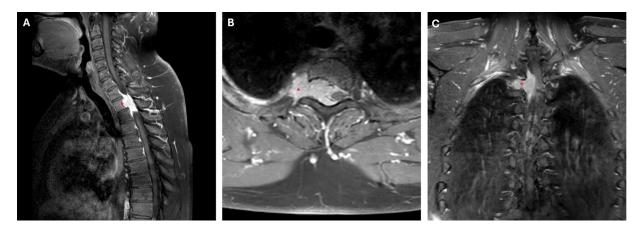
Preoperative cervico-thoracic spine magnetic resonance imaging (MRI). Sagittal (A), axial (B), and coronal T1-weighted images (C) with Gadolinium contrast reveal a large intra- and extra-vertebral lesion on the right side, likely extradural, with significant homogeneous enhancement (red asterisks). The dumbbell-shaped mass, measuring approximately $50 \times 35 \times 14$ mm, causes bony remodeling of the right posterior vertebral body of Th2, widening the ipsilateral neural foramen and extending extraforaminal to the costovertebral joint. The lesion occupies a large part of the spinal canal, forming a "sleeve" around the spinal cord and displacing it to the left (Eden type 3). This picture is from Garibaldi Hospital, Catania, Italy, and informed consent was obtained from the patient for this study.
